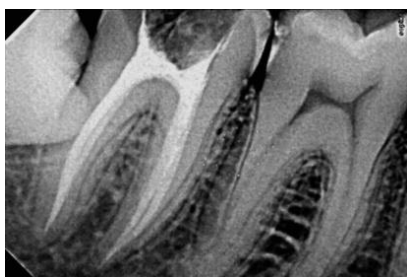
Intra Oral periapical radiograph showing retrieval of separated instrument
